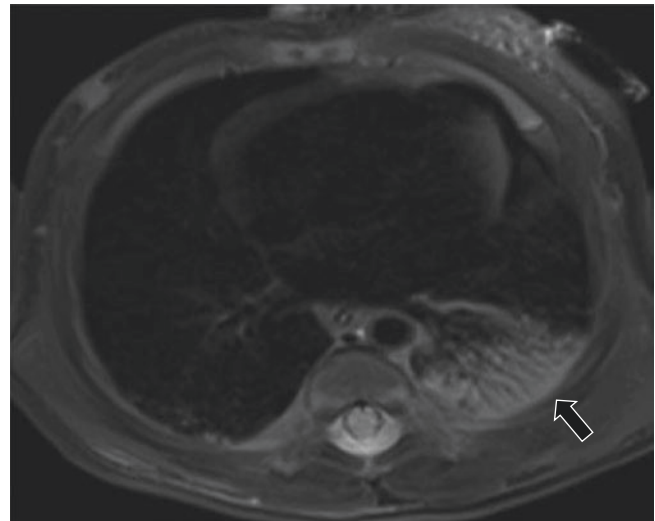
Aspiration pneumonia in a 3-week-old girl who presented with fever and respiratory distress. Axial non-enhanced T2-weighted fat-suppressed MR image shows left lower lobe consolidation (*arrow*)
